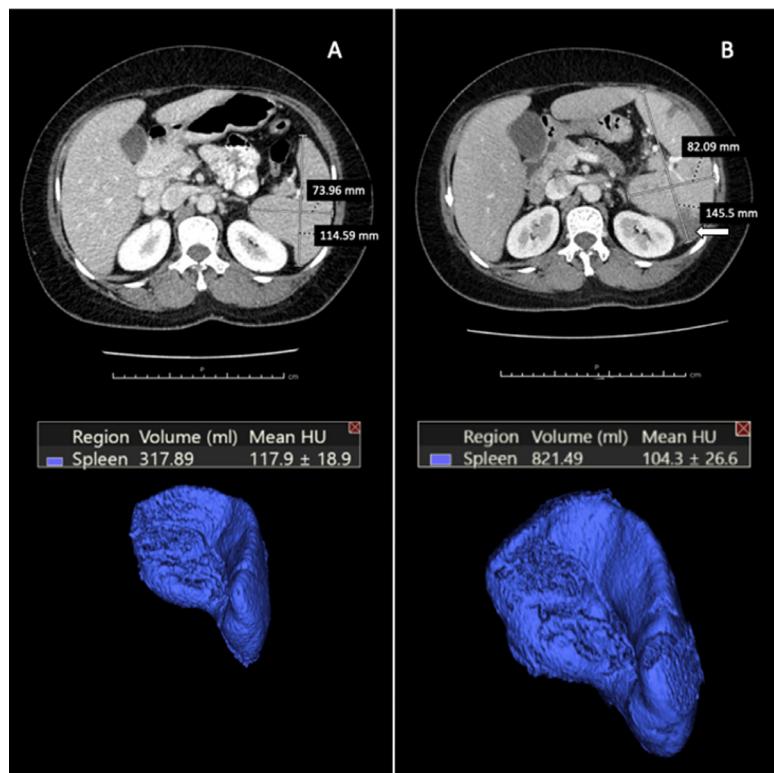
A) Contrast computed tomography scan performed at the first admission. B) Second contrast computed tomography scan, taken at the second week, showing progressive hepatosplenomegaly with multifocal splenic infarction without splenic vein thrombosis. An ultrasound-guided, percutaneous splenic biopsy was performed at the posterior aspect of the spleen (arrow).
